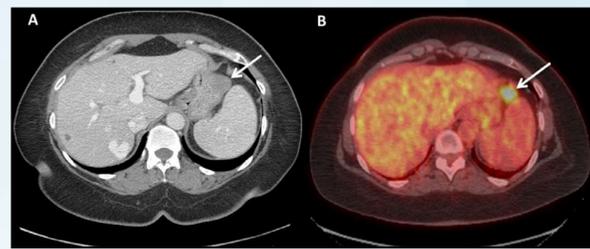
Case 2 with CT abdomen/pelvis image of 2.9cm exophytic mass in the gastric body (A) with staging PET scan for stage 2 breast cancer showing intense focal FDG uptake within the same corresponding area. (B)
